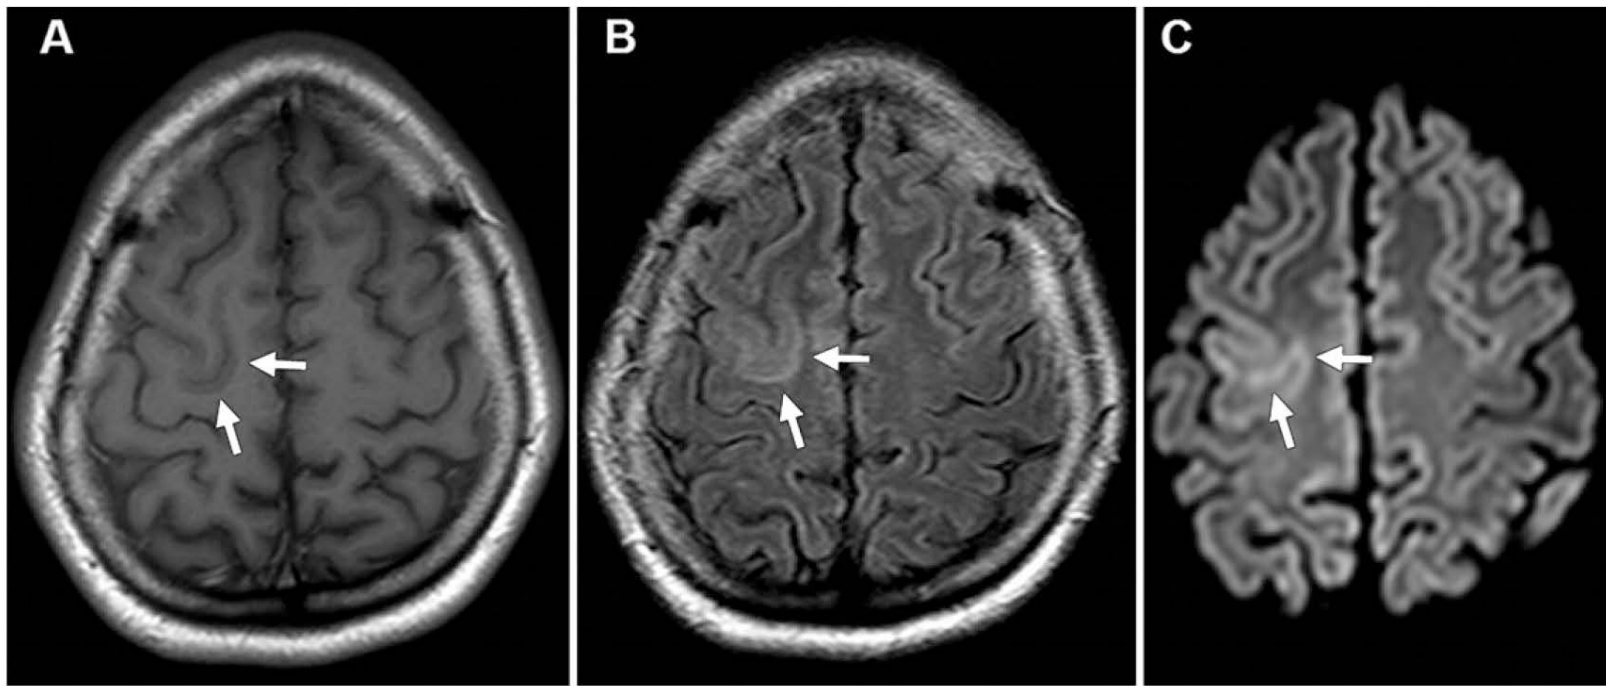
Axial MR images in 32-year-old patient with asymptomatic NTZ PML involving right precentral sulcus. A, NTZ PML lesion is confined in U fibers, slightly hypointense on T1-weighted image (arrows) and hyperintense on, B, FLAIR and, C, DW images (arrows).
